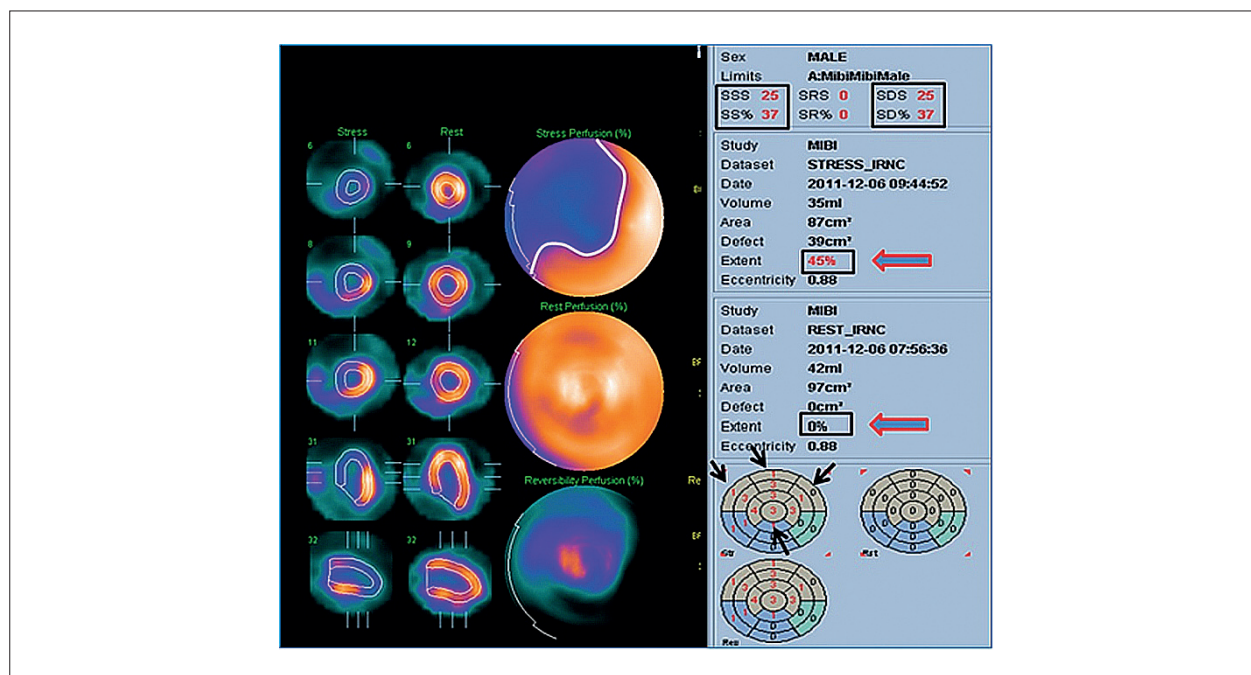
MPS GATED-SPECT: large-extent stress-induced ischemia. A large area of hypoperfusion is observed, involving the anterior wall, septal region, and apex, extending distally to the inferior and lateral walls. This is visualized in blue on the stress polar map (PM) (upper left image), delineated by a white contour line. The PM representing rest perfusion shows a homogeneous distribution of the radiotracer, indicating normal perfusion. The graphical representation of stress scores (black arrows) shows the numerical grading of hypoperfusion intensity and the number of affected segments (bottom right corner), with summed scores of SSS = 25, SRS = 0, and SDS = 25 (top right corner), along with an estimated myocardial ischemic burden of 45% of the left ventricle. Invasive coronary angiography revealed a proximal subocclusive lesion in the anterior descending artery. MPS GATED-SPECT: myocardial perfusion scintigraphy gated single photon emission computed tomography; SDS: summed difference score; SRS: summed rest score; SSS: summed stress score. Source: Personal archive.
